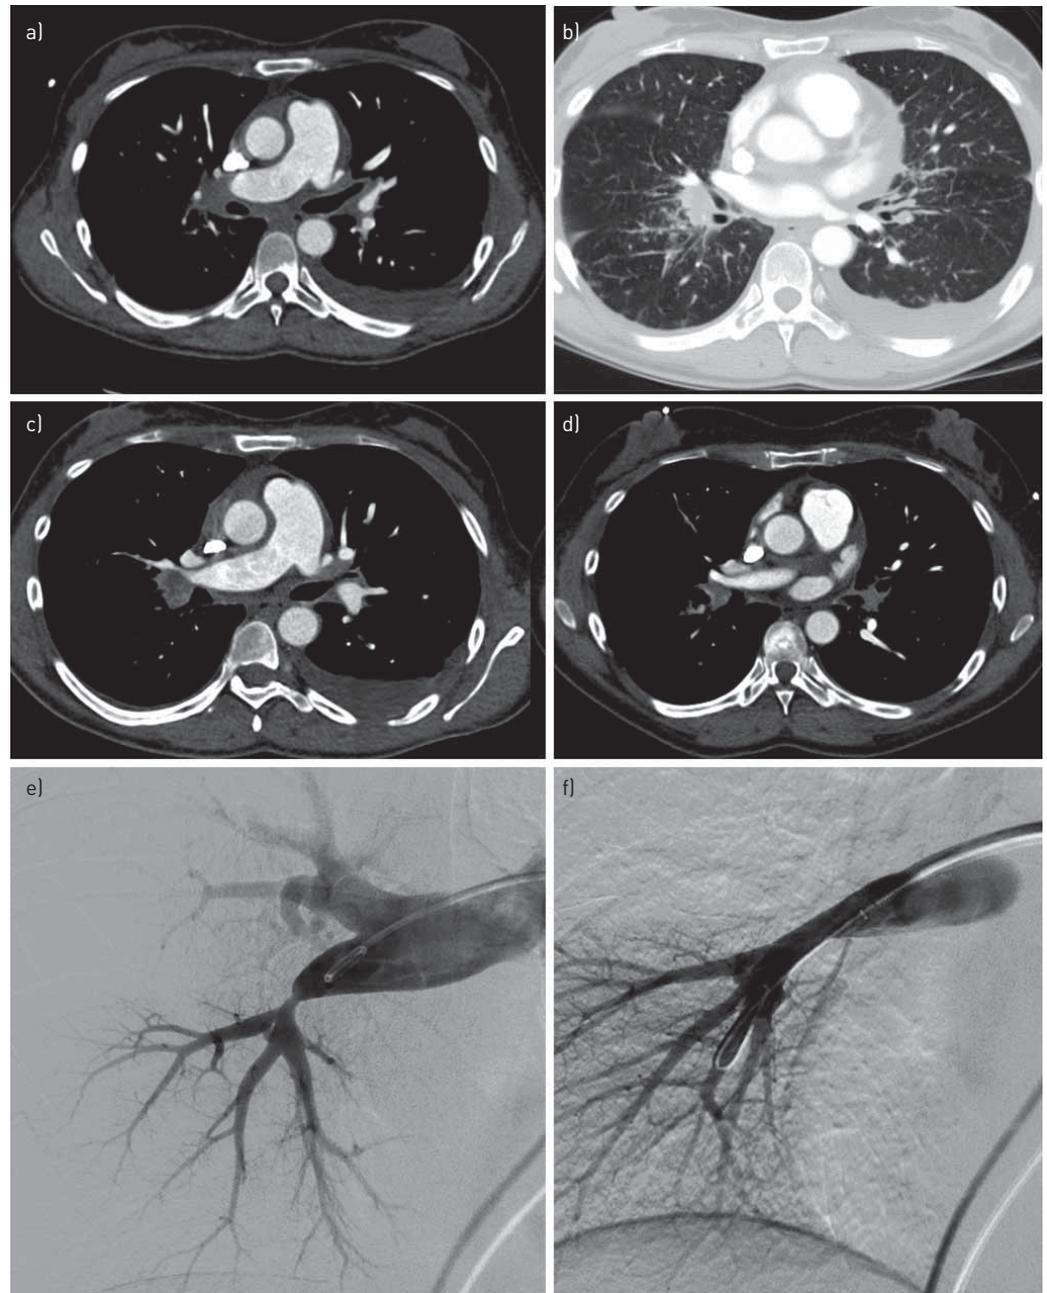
Overview of the computed tomography pulmonary angiography (CTPA) and pulmonary angiography before and after balloon pulmonary angioplasty (BPA). CTPA pre-BPA: a) Mediastinal setting shows bilateral hilar and mediastinal lymphadenopathy. b) Lung setting shows multiple small bilateral nodules with perilymphatic distribution and pleural fluid on the left. c) Severe narrowing of the lumen of the origin of the middle lobe artery with more than 50% loss of the lumen owing to external compression. CTPA post-BPA: d) Increase in the diameter of the lumen of the origin of the middle lobe artery. e) Pulmonary angiography pre-BPA with an 18-grade left anterior oblique view shows stenosis of the origin of the middle lobe artery. f) Pulmonary angiography after BPA with an 18-grade left anterior oblique view shows that the narrowed lumen of the origin of the right middle lobe artery was completely resolved with good filling of the peripheral branches.
